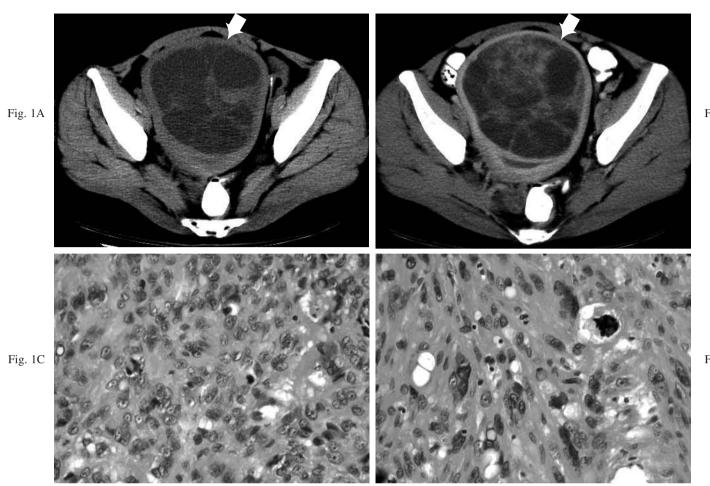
Palpable mass in the lower quadrant of the patient's abdomen with increased menstrual flow for two months. (A) CT scan without contrast enhancement showing a heterogeneous cystic tumor (arrow) in the uterus.
